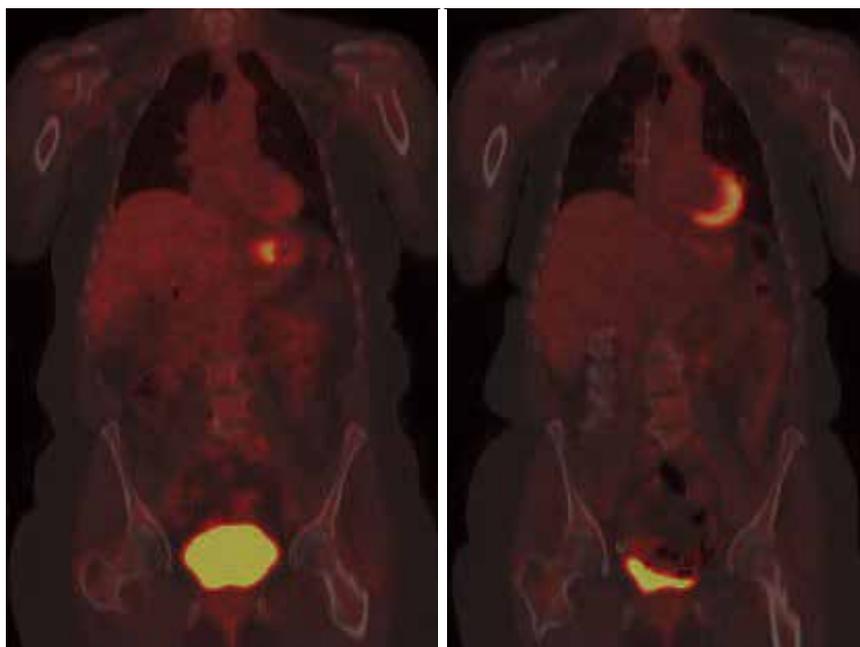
CT-PET at diagnosis shows uptake in the proximal stomach. After therapy, uptake is visibly reduced.
